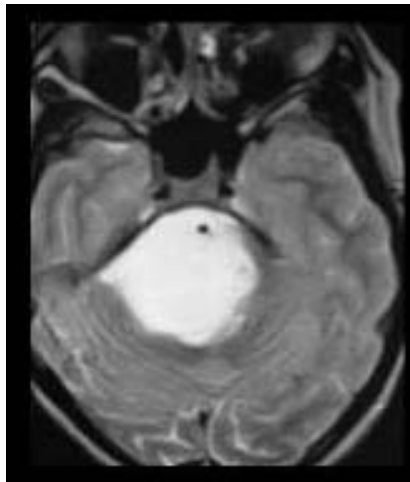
Axial T₂-weighted MR image showing a diffuse pontine glioma
